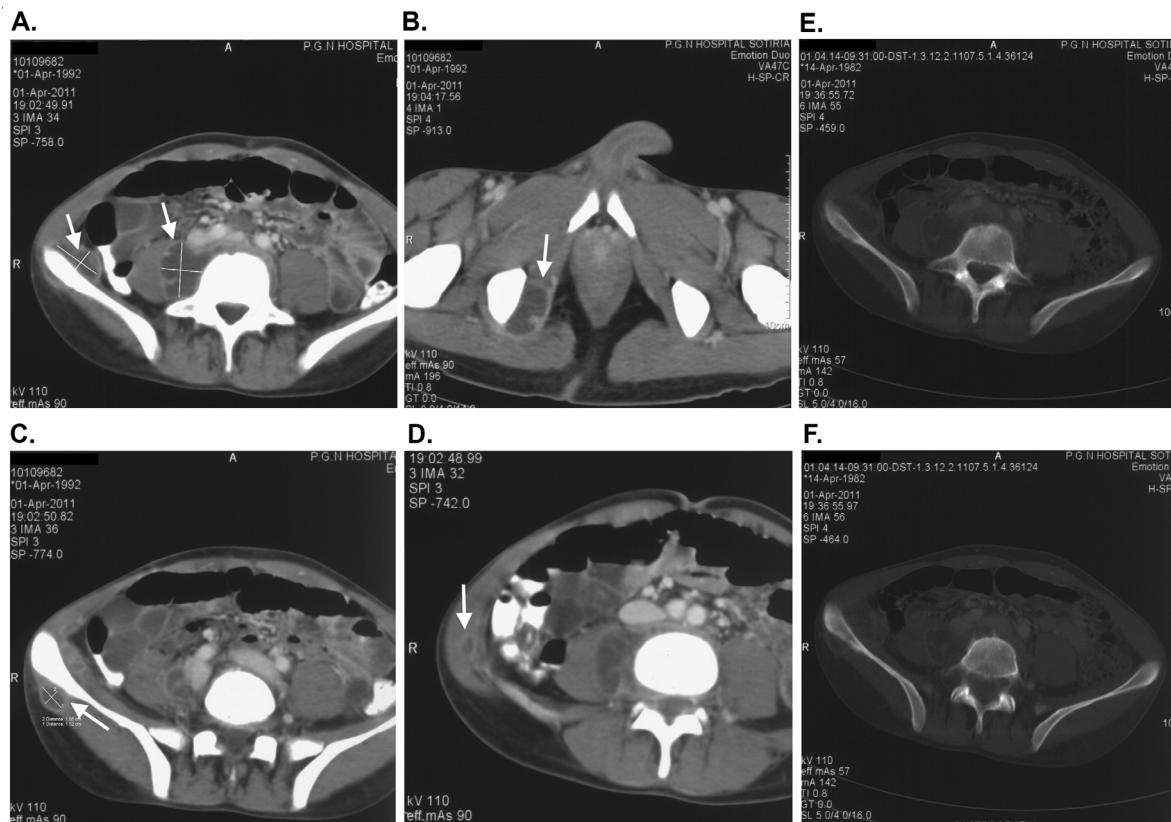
Computed tomography (CT) scan of the abdomen depicting (with white arrows) well defined abscesses (low density areas with peripheral enhancement after intravenous administration of contrast media) in the vicinity of the right psoas and iliacus (A), internal obturator (B), middle gluteal (C) and internal oblique muscles (D). Finally minor lytic lesions can be observed in the outer edge of the right iliac crest, near the iliacus and gluteal abscesses in (E) and (F).
